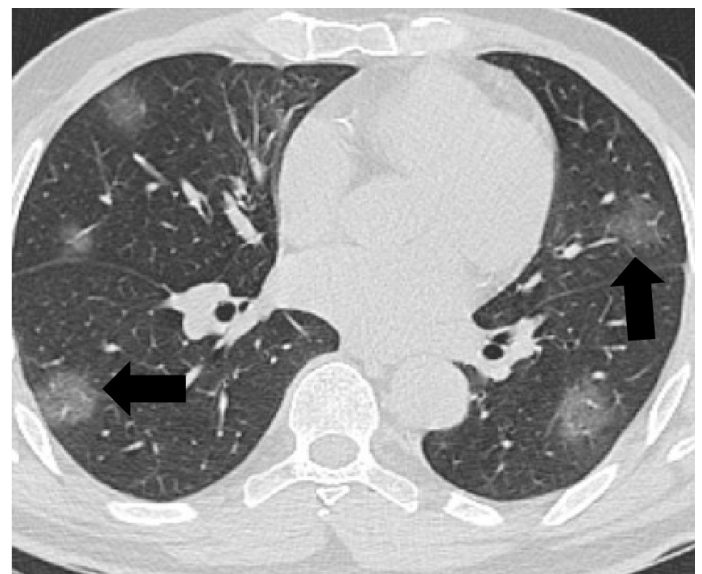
55-year-old man who presented with chest pain, fever and cough for 3 days. Coronavirus disease (Covid-19) had recently been diagnosed in two of his household members. Axial CT image shows peripheral nodular ground-glass opacities (arrows)
